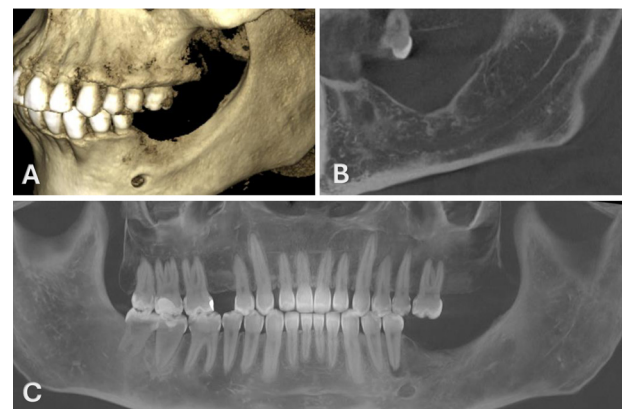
CBCT at 6 month post-operative. A) 3D reconstruction showing the healed bone defect B) Sagittal section showing satisfactory reossification, with a residual vertical defect C) Panoramic reconstruction showing healing in sector 3, extraction sites 15, 27, 28, 36. Endo (35), restorations (25, 46) were subsequently carried out.
